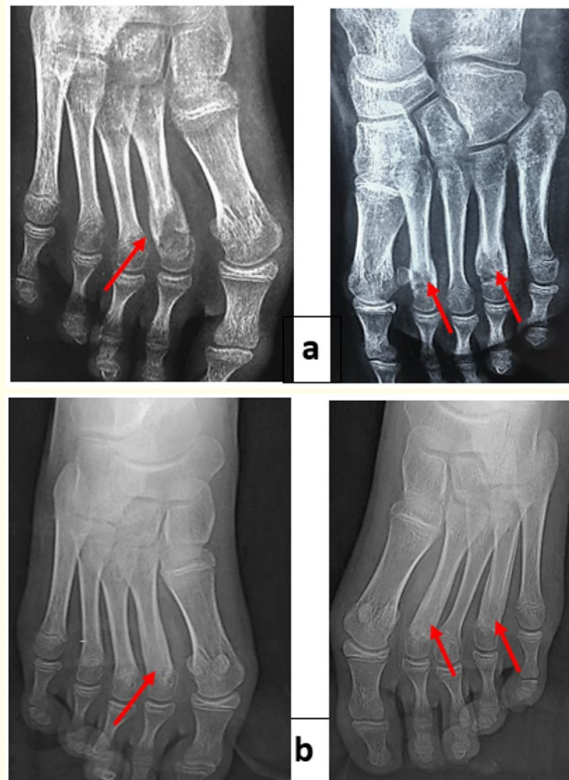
X-rays of both feet.
